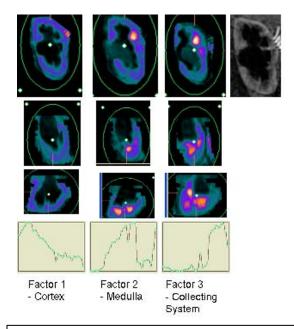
Factor Images (color images) and Time-Intensity Curves (bottom row) in a Hydronephrotic Obstructed Kidney. Contrast-enhanced T1-weighted MR image (top right).
